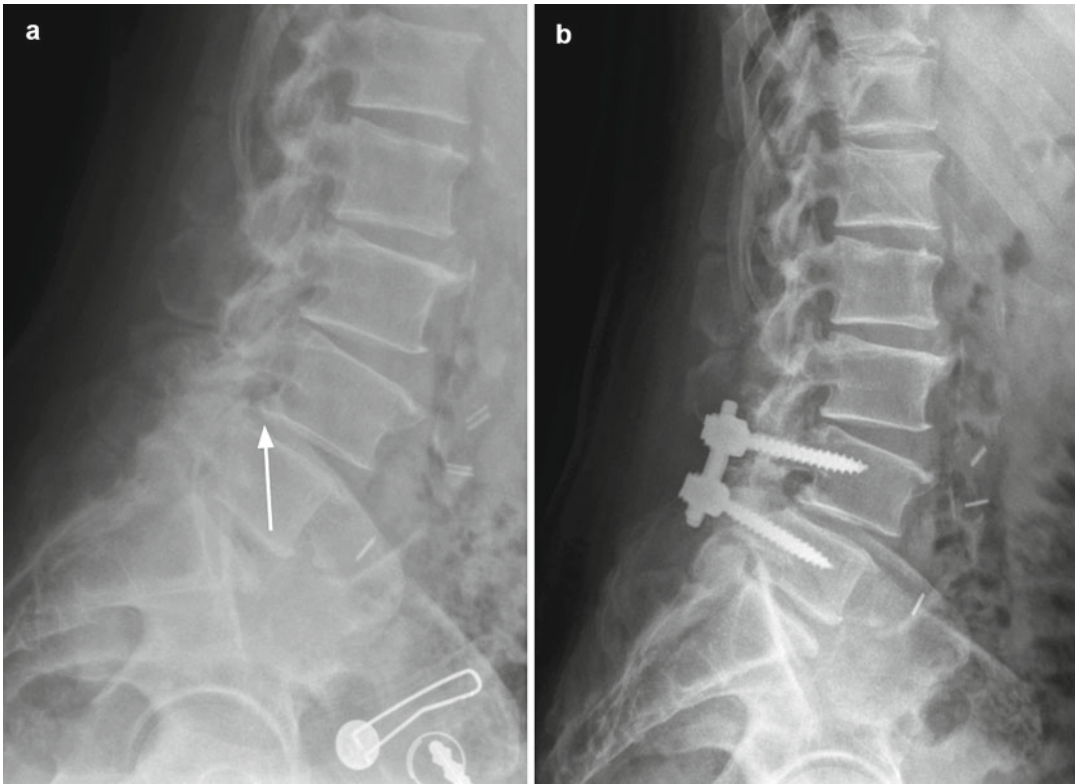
(a) Lateral x-ray of lumbar spine. The arrow points to a Grade I spondylolisthesis. (b) Postoperative lateral x-ray showing pedicle screw and rod fixation after
